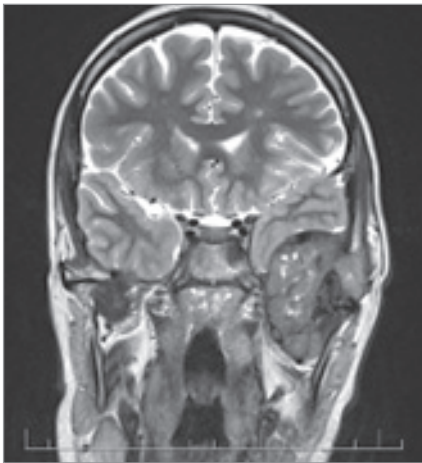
Pre-operative MRI – first case.
